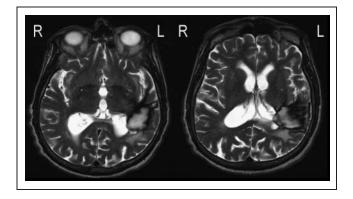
The lesion. A T2-weighted MRI (TE = 122 msec; TR = 8690 msec) at 4 months shows a left temporal–parietal hematoma in resorption with extended destruction of the posterior superior temporal lobe (area 22, including Wernicke's area) and the white matter underlying areas 22 and 40, including the arcuate fasciculus in the temporal stem.
